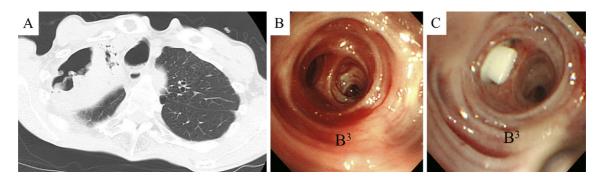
Chest computed tomography taken at admission. Fluid retention and amorphous matter in the bullous cavity at the right lung apex are shown (A). Bronchoscopic findings on days 7 (B) and 9 of hospitalization (C). Active bleeding from the right B³b is shown (B). A 7-mm spigot was placed in the right B³b (C).
